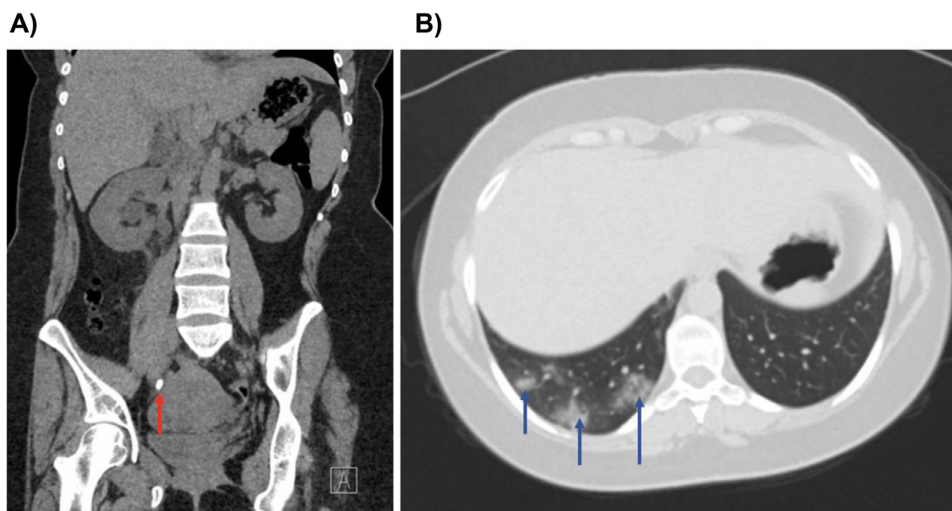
CT images of (A) right distal ureteric stone (red arrow); (B) ground-glass appearance in right lung base (blue arrows). (Color version is available online.)
